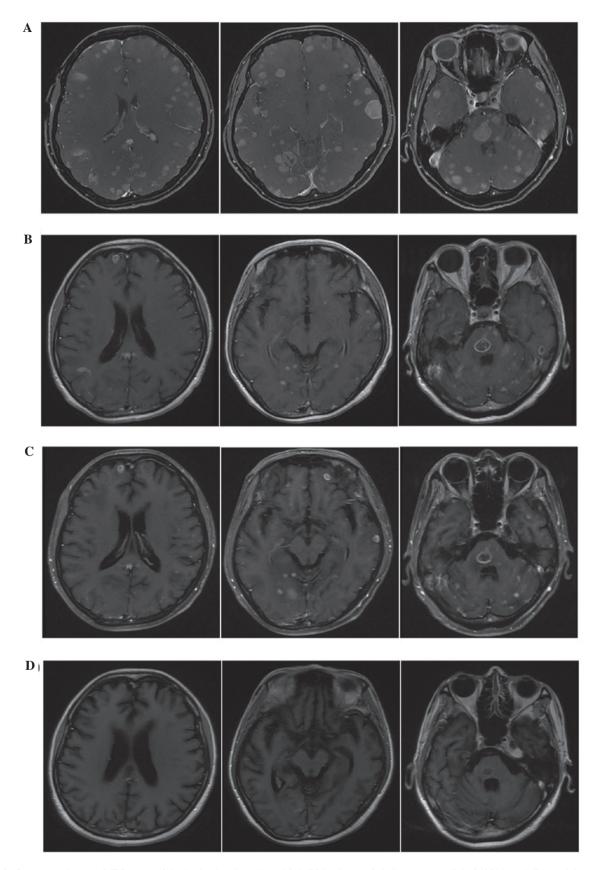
Contrast-enhanced MRI scans of the brain showing (A) multiple BM prior to afatinib treatment (July 9, 2014) and (B) partial response to afatinib treatment with concurrent whole-brain radiotherapy (August 27, 2014). (C) BM remained stable after 3 months of afatinib therapy (October 8, 2014). (D) Marked partial response was observed in the BM following the addition of bevacizumab to afatinib treatment (January 14, 2015).
